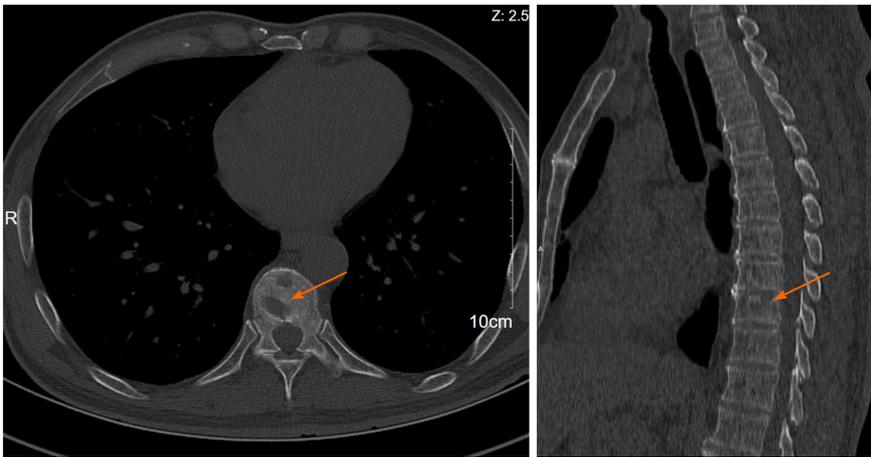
Computed tomography scan of the chest showing an osteolytic lesion in T10 vertebral body (orange arrow).
